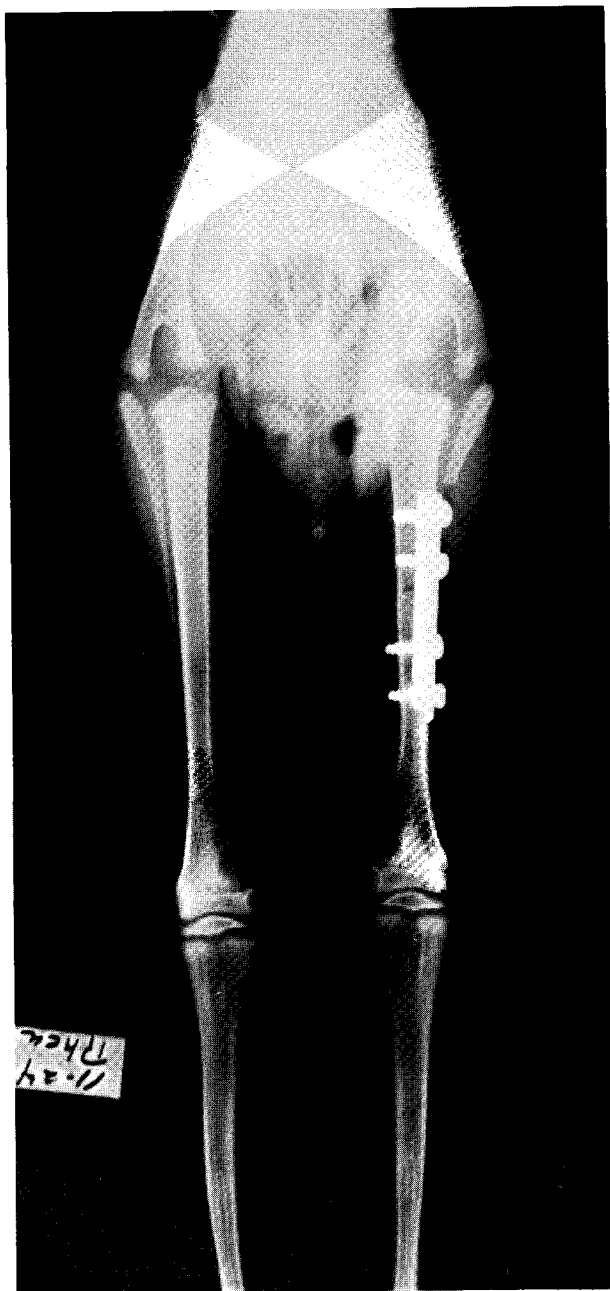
A postoperative anteroposterior radiograph following osteotomy and rotation of tibia. A four-hole semi-tubular bone plate is holding the leg in good anatomical position.
